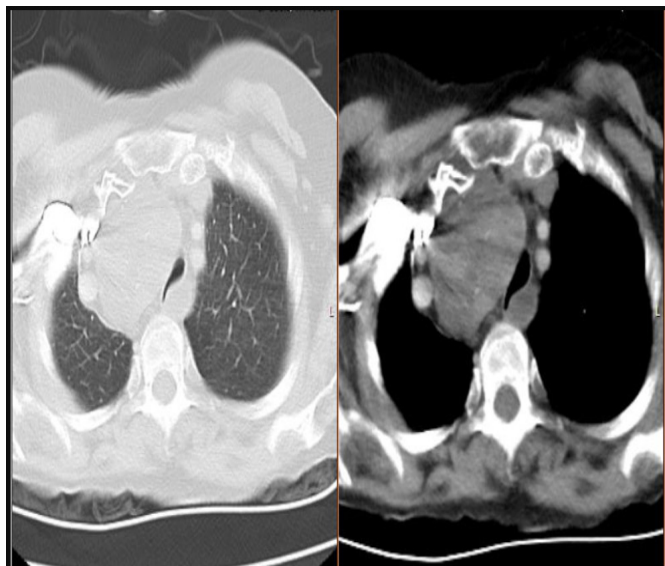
Chest computed tomography revealed a giant mass lesion pressured on the trachea from the right side
